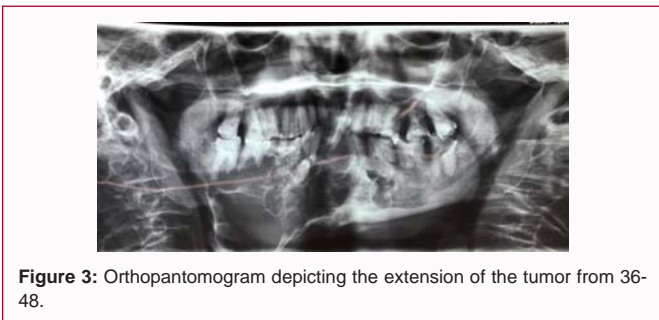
Orthopantomogram depicting the extension of the tumor from 36-48.
